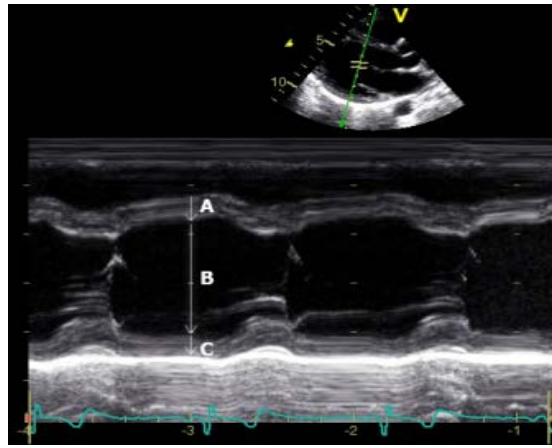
M-mode echocardiography image of the left ventricle in parasternal axis view. A=Septal Wall Thickness in diastole (SWTd). B=LV Internal Diameter in diastole (LVIDd). C=Posterior Wall Thickness in diastole (PWTd).
